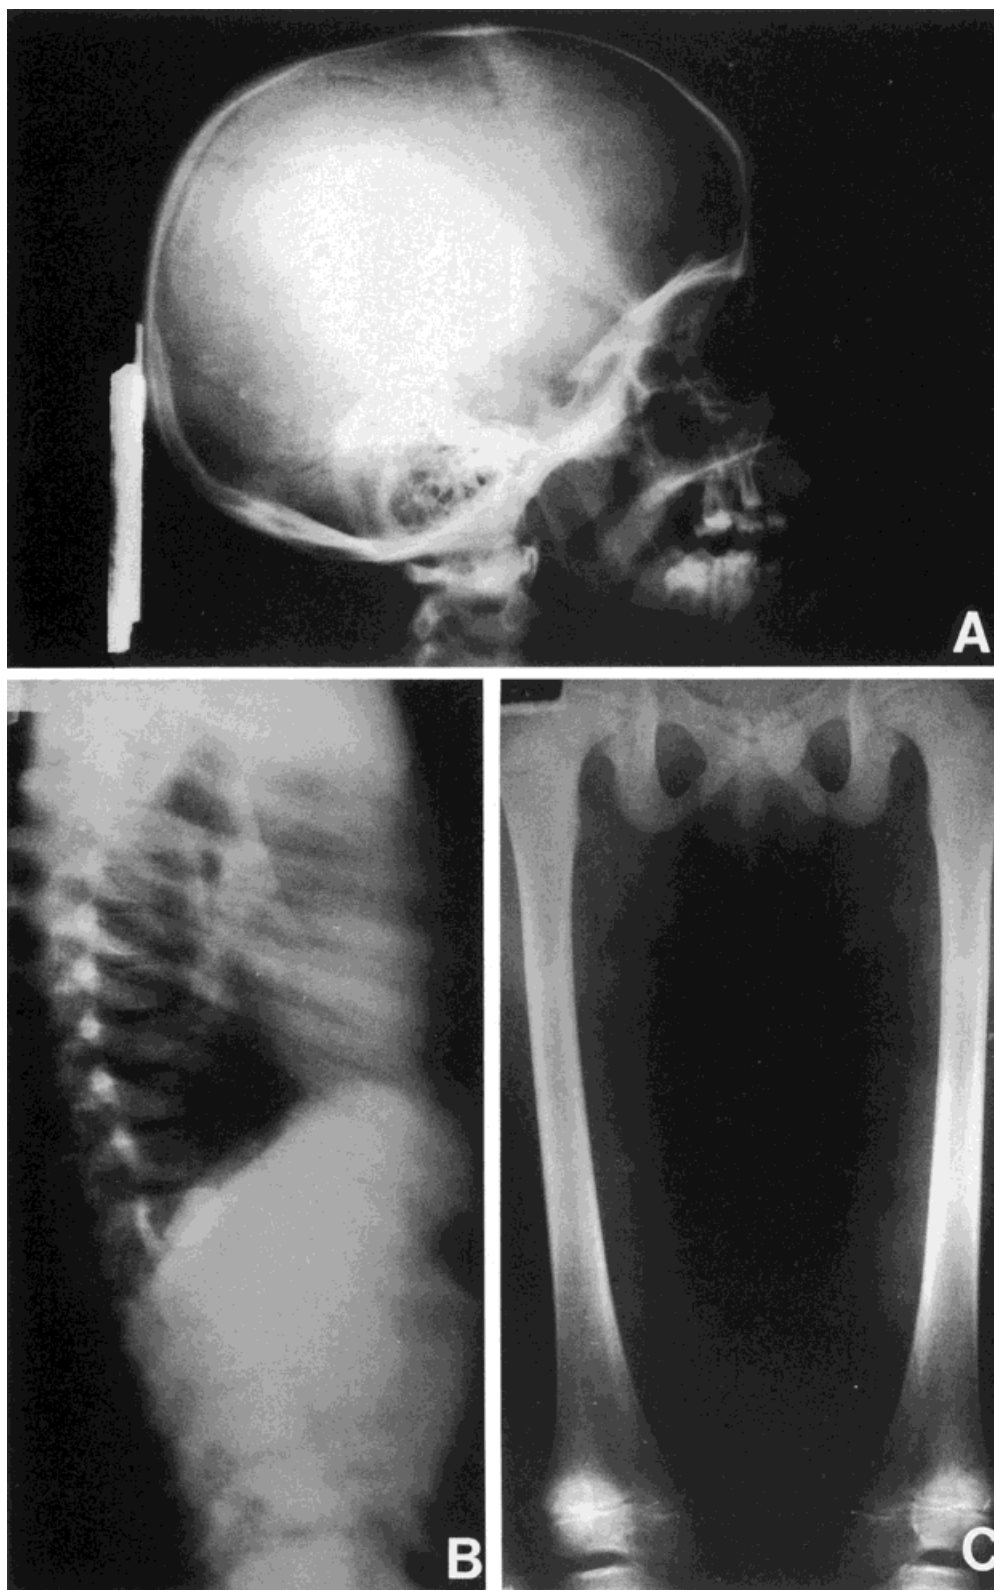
Patient A, X-rays at age, 10 years. Note: (A) Verticalized posterior fossa; (B) narrow thorax and ovoid-shape vertebral bodies; (C) the medullary canals and metaphyses more broadened.
